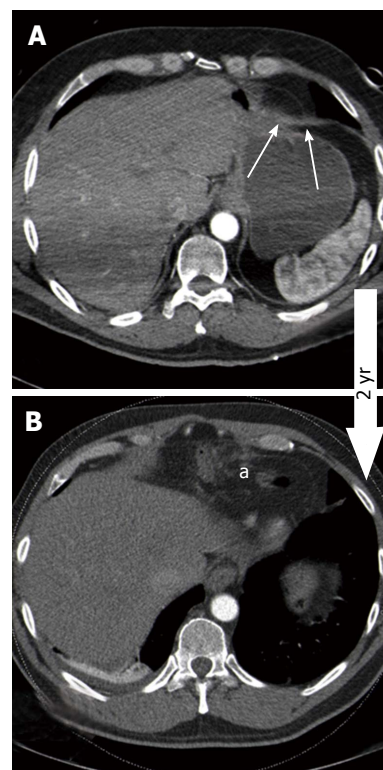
False negative case of blunt diaphragmatic lesions. Three millimeters thick axial CT images of the same patient, acquired after a precipitation trauma (A) and two years later (B). Thickening of the antero-medial part of the left hemidiaphragm (A, arrows) was overlooked at the first CT scan, performed after a precipitation trauma. Two years later, a CT scan performed because of epigastric pain showed intra-thoracic viscera herniation (B, "a") as a consequence of diaphragmatic rupture. CT: Computed tomography.
